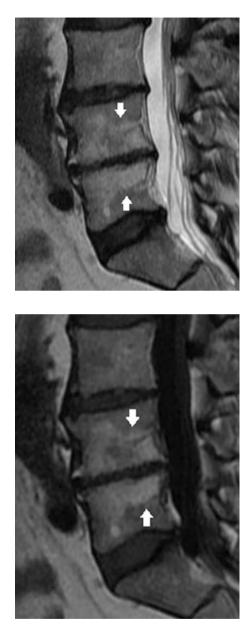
Type II Modic endplate changes (*white arrows*) on T1-weighted MRI
